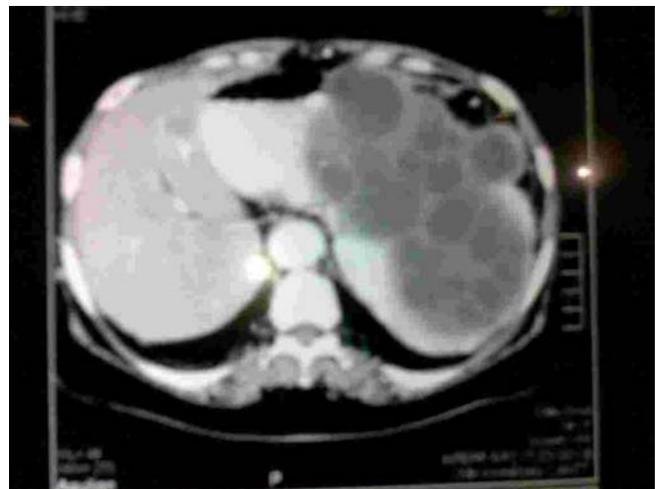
CT scan abdomen showing hydatid cyst in the spleen
